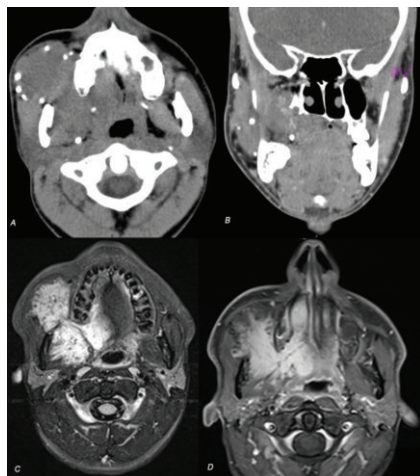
A) Axial and B) coronal computed tomography scan obtained with contrast material shows dilated vessels that extend into the infratemporal area and multiple phleboliths can be seen. C) and D) Axial T2 weighted magnetic resonance image shows high intensity lesion with flow representing vessels of different sizes.
